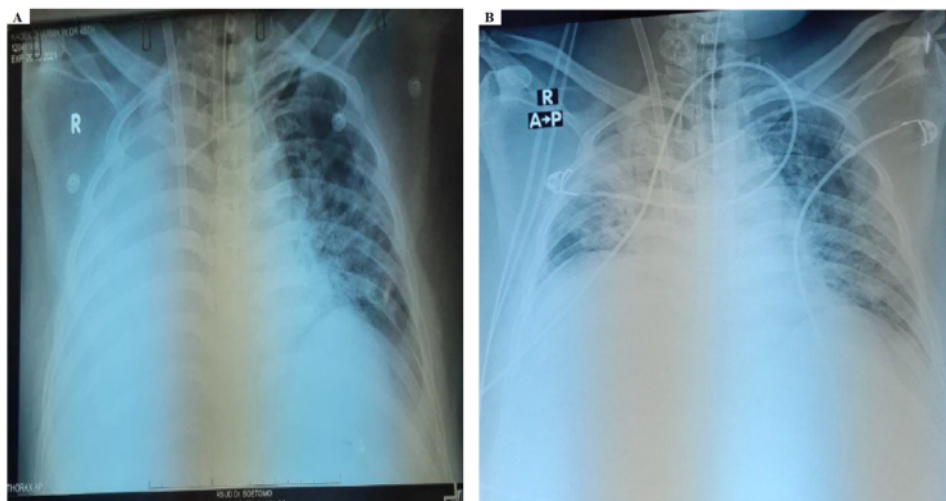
X-ray examination results on the first participant.
